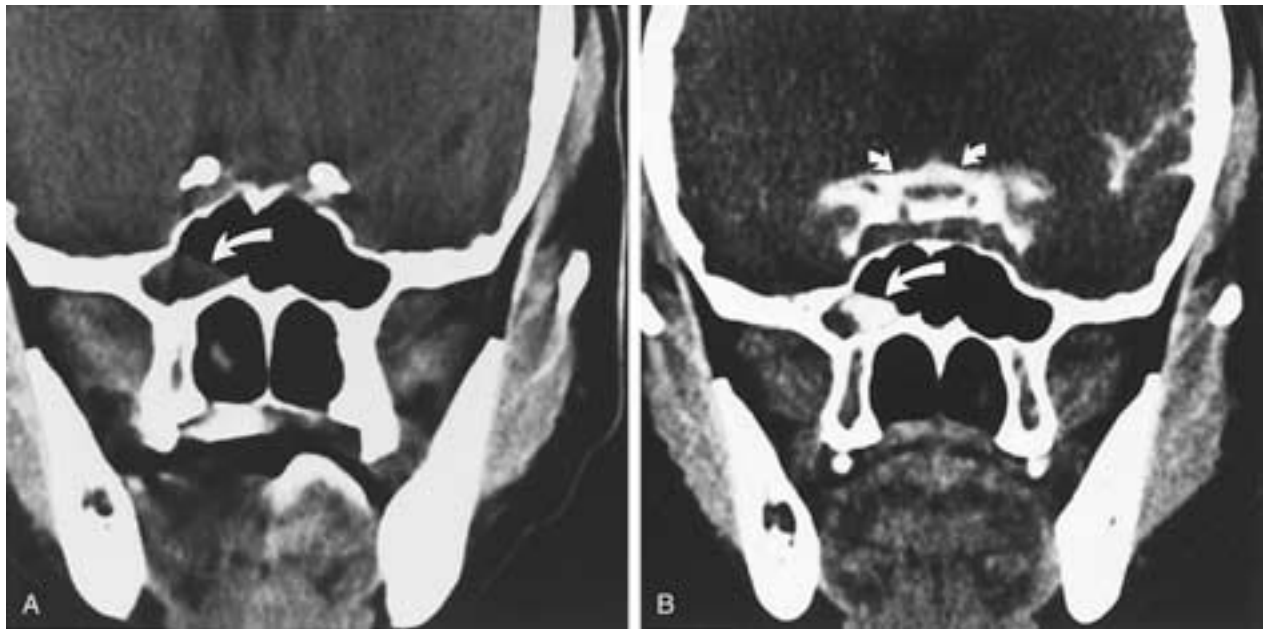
A 25-year-old male after head trauma with persistent CSF rhinorrhea and recurrent meningitis. Traumatic CSF fistula demonstrated by water-soluble contrast cisternography. Coronal CT scan through the sphenoid sinus obtained. Before A and following B, the intrathecal instillation of water-soluble contrast material. A soft-tissue density is appreciated involving the right lateral floor of the sphenoid sinus (*curved arrow*), as seen on the study before the instillation of contrast material. Following the instillation of contrast, increased density is appreciated in this region, consistent with the accumulation of contrast, documenting the presence of a CSF fistula. Also noted is the presence of contrast material within the suprasellar cistern (*small curved arrows*) outlining the chiasm and vascular structures. The fracture site was not identified.
